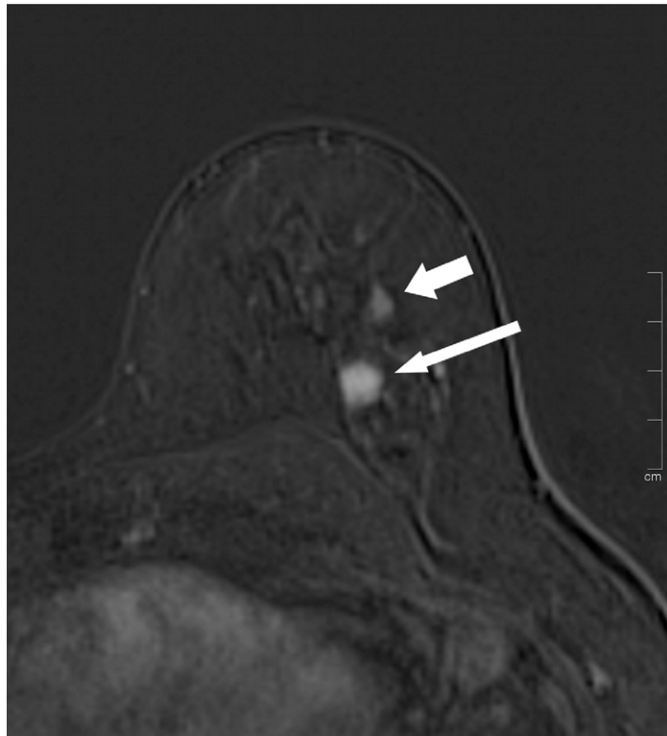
MRI: T1 weighted subtraction MR image of the left breast after intravenous contrast-agent application in axial projection (slice thickness 2.5 mm, sequence: T1 weighted 3D fast low angle shot, TR 7.24 ms, TE 2.38 ms). The long white arrow points at lesion A, the short white arrow at lesion B.
